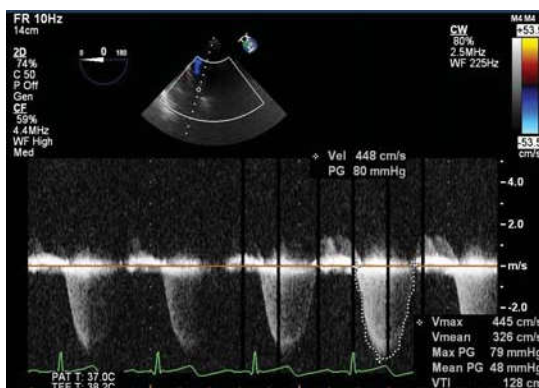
Transesophageal Echocardiographic image wherein continuous wave Doppler is applied in the Deep Transgastric long axis view at 0 degree, showing peak gradient of 80 mm Hg across left ventricular outflow tract.
